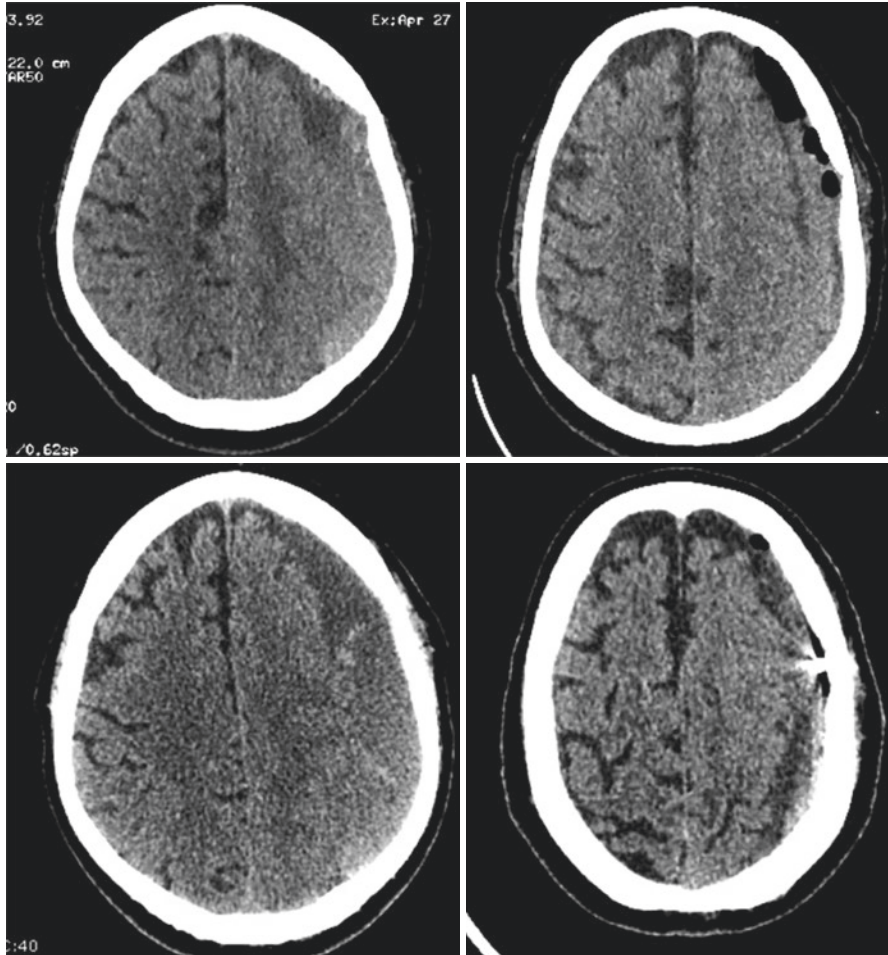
Computed tomography (CT) of the head on initial presentation showed a mixed density subacute and chronic left convexity subdural hematoma (SDH) (top left). Decreased size of the hematoma is seen after subdural bolt placement (top right). Recurrence occurred after 2 weeks (bottom left), which again improved after a repeat bolt drainage procedure (bottom right)
